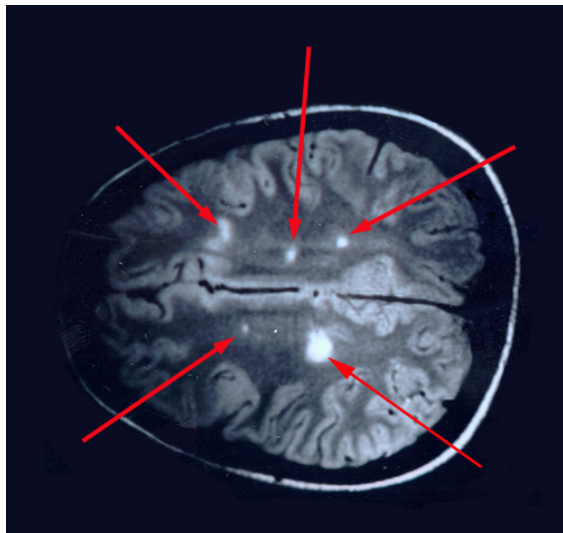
MRI of the brains
